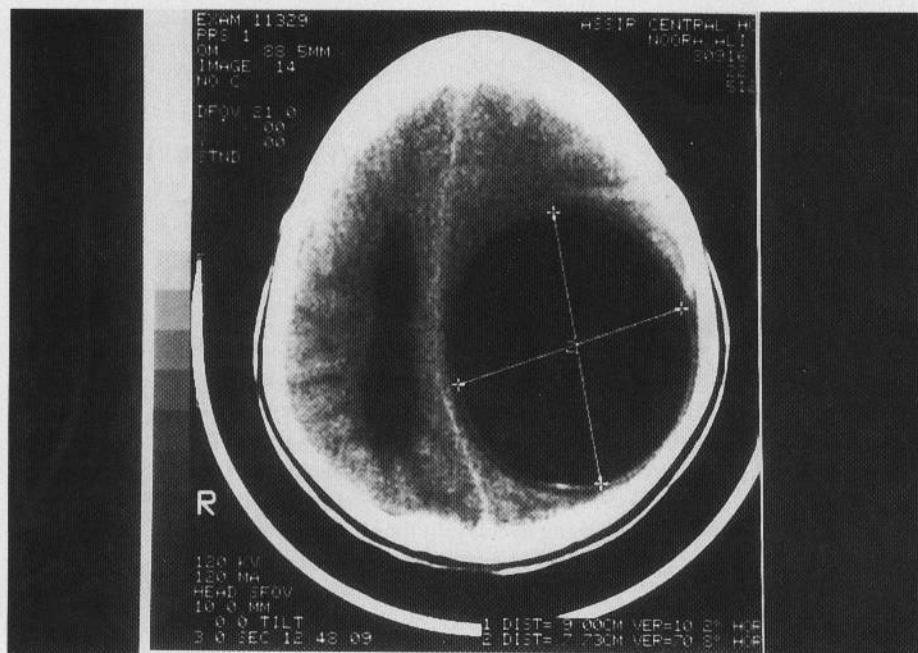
CT scan of the brain showing a large hydatid cyst in the left parieto-temporal region.
